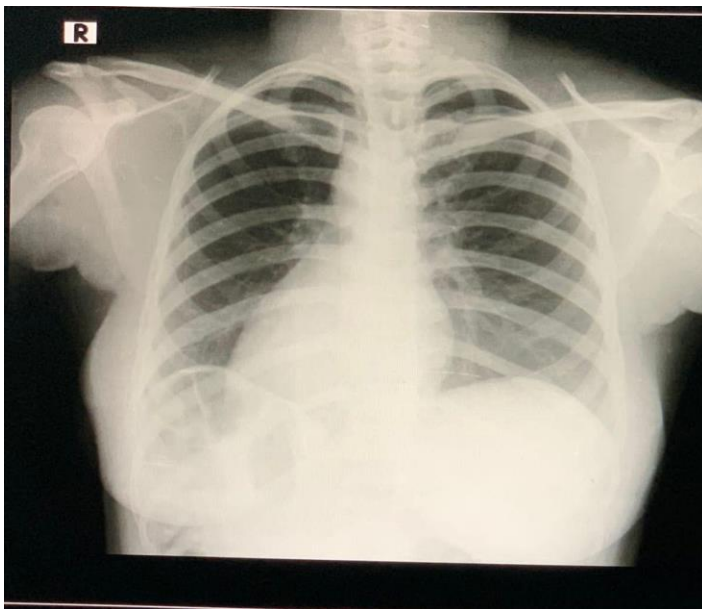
Patient's Chest X-ray Demonstrating Dextrocardia
